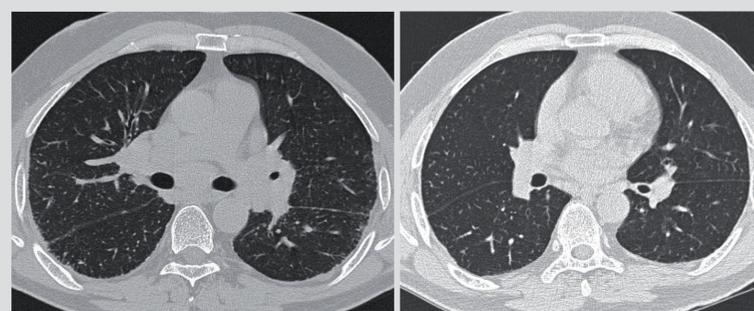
HRCT images of patient 1 before (left) and after (right) treatment with Adalimumab.
